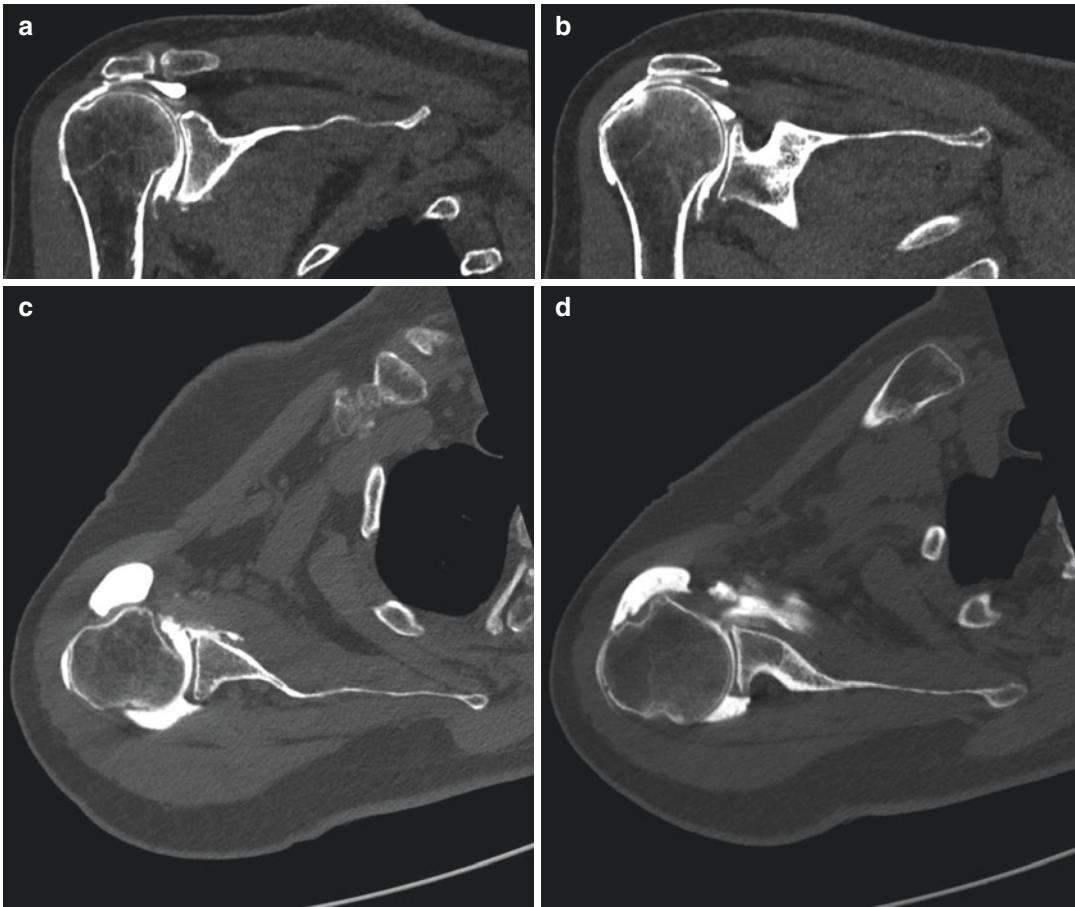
CTA of the right shoulder: Coronal reconstruction shows a minor SLAP lesion (a) and a SSP lesion with cranial translation (b). On transverse reconstruction a Bankart lesion (c) and a Hill-Sachs lesion (d) were seen
